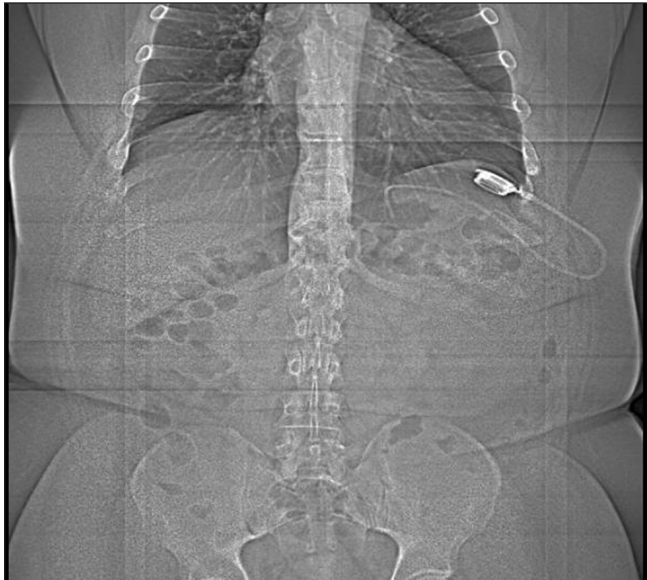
Reconstruction image of the abdominal computed tomography scan showing intragastric penetration of the connection tube with no gastric band.
